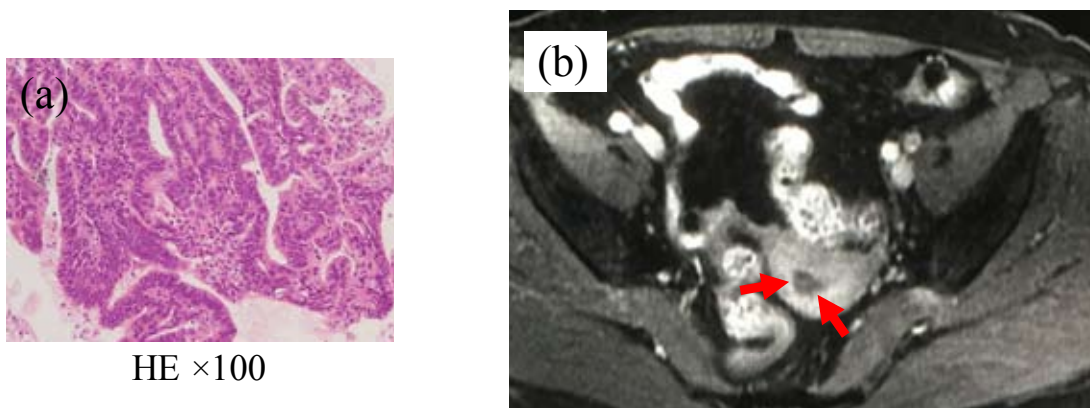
The findings of pathological examination and magnetic resonance imaging (MRI) before operation. Endometrial carcinoma grade 1 was detected by the endometrial biopsy (a). The size of tumor was less than 2cm (arrow), and its invasion was less than a half of the myometrium (b).
